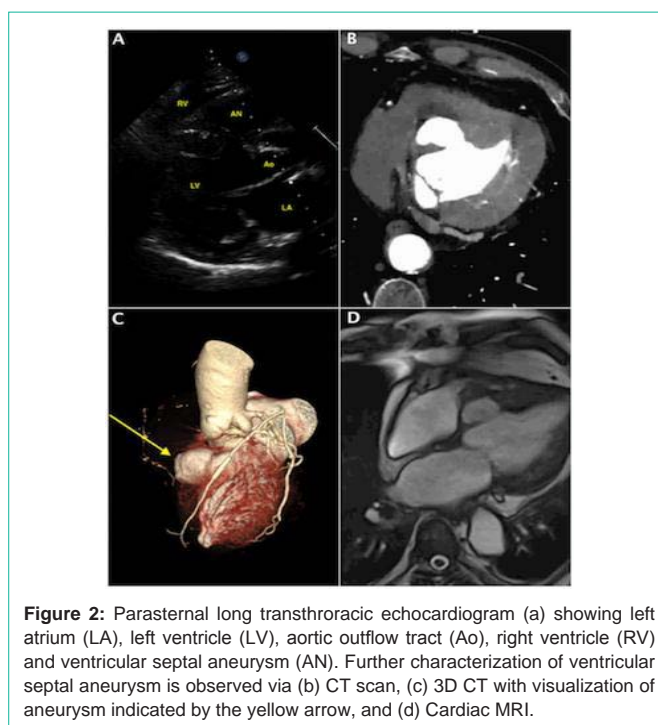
Parasternal long transthoracic echocardiogram (a) showing left atrium (LA), left ventricle (LV), aortic outflow tract (Ao), right ventricle (RV) and ventricular septal aneurysm (AN). Further characterization of ventricular septal aneurysm is observed via (b) CT scan, (c) 3D CT with visualization of aneurysm indicated by the yellow arrow, and (d) Cardiac MRI.
